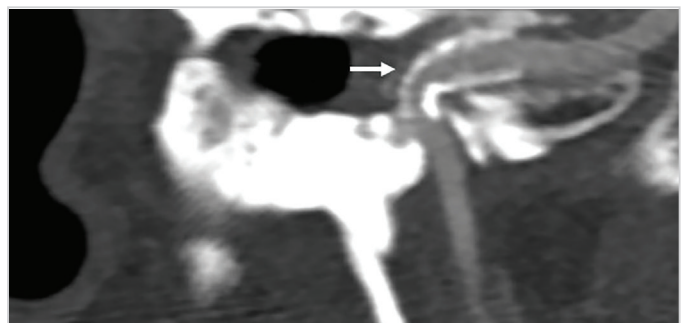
Computed tomography angiography reconstruction showing the carotid stent (arrow)
